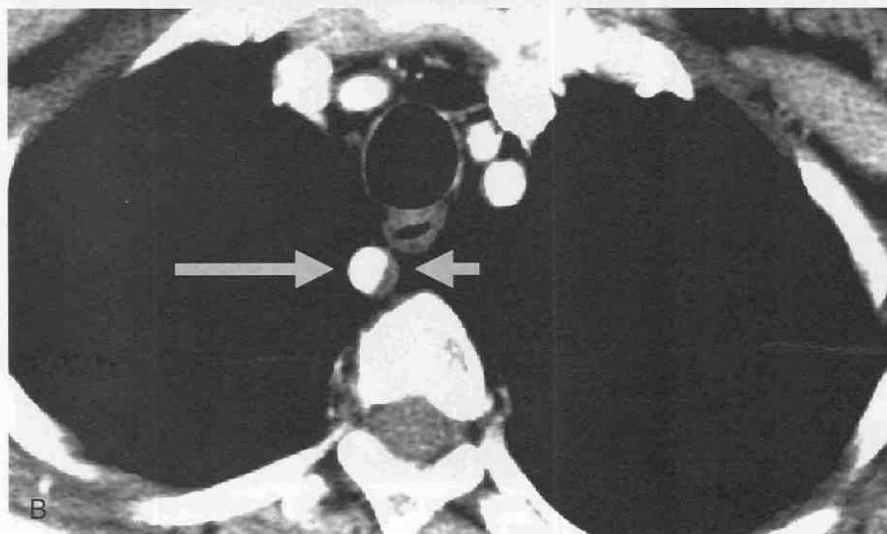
A, Axial CT scan shows an anomalous vessel crossing behind the esophagus, consistent with aberrant right subclavian artery (arrow). B, Axial CT scan shows the aberrant subclavian posterior to the esophagus. Note the eccentric thickening of the subclavian artery, consistent with early atherosclerotic change. C, Shaded surface display shows the position of the aberrant right subclavian artery (arrow).
